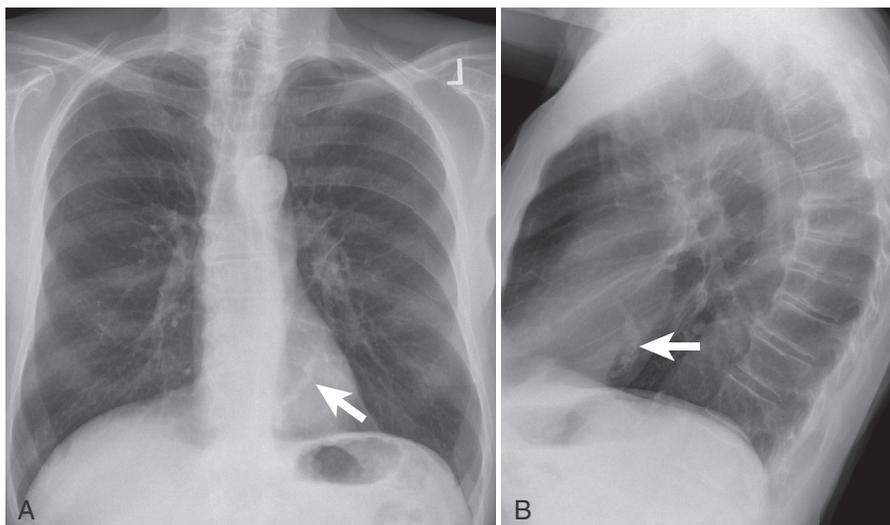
PA (A) and lateral (B) chest radiographs in a patient with mitral annular calcification (*arrows*).
